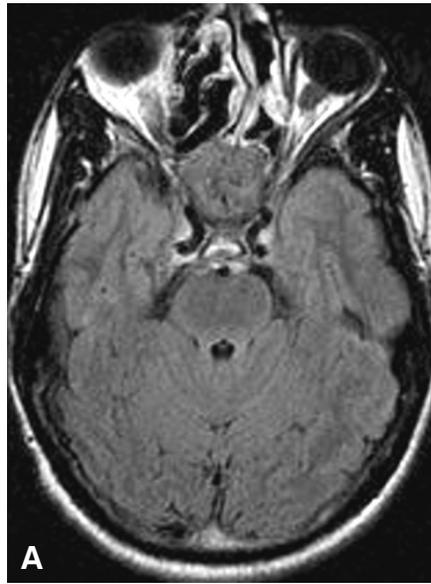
(A) T1- and (B) T2-weighted MR images show an isointense lesion occupying the sphenoid sinus and sella.
